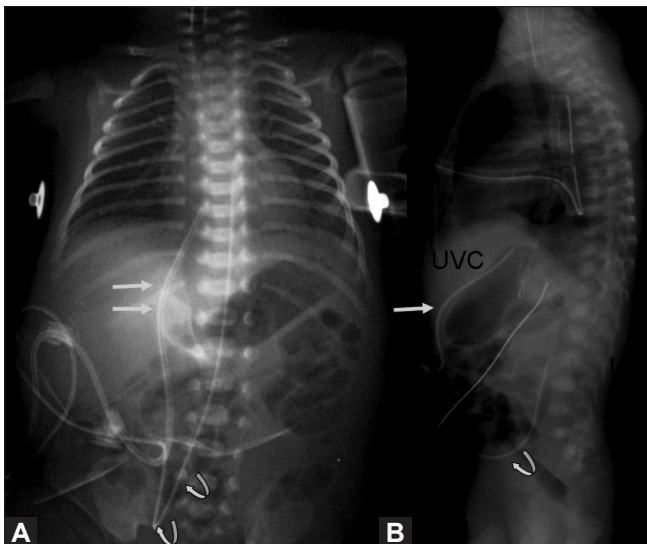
(A, B): Frontal (A) and lateral (B) radiographs of the chest and abdomen of a neonate demonstrate the correct position of an umbilical venous catheter (to the right of the spine) and an umbilical artery catheter (high position). Note the curve of the venous catheter as it passes through the portal sinus (arrows) and the classical dip of the arterial catheter in its proximal course (curved arrows)
